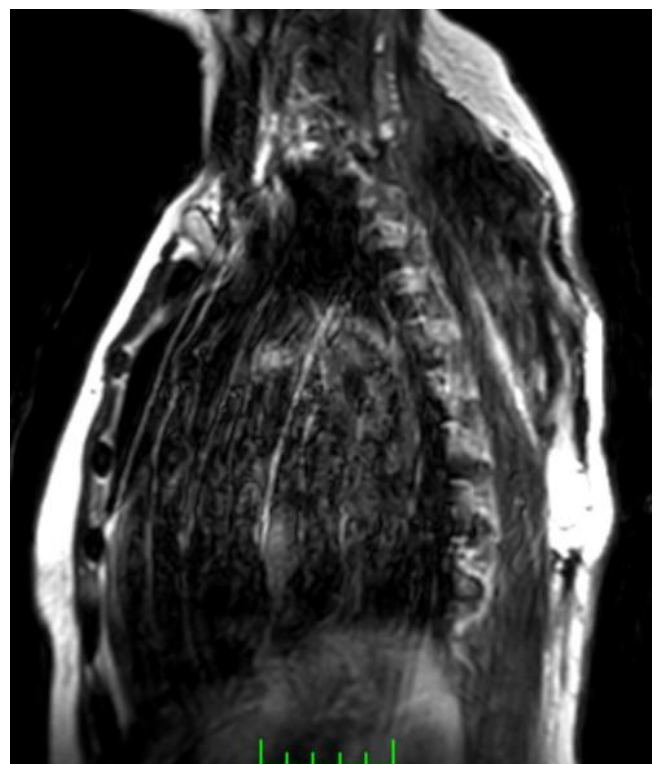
MRI image of the patient (sagittal)
